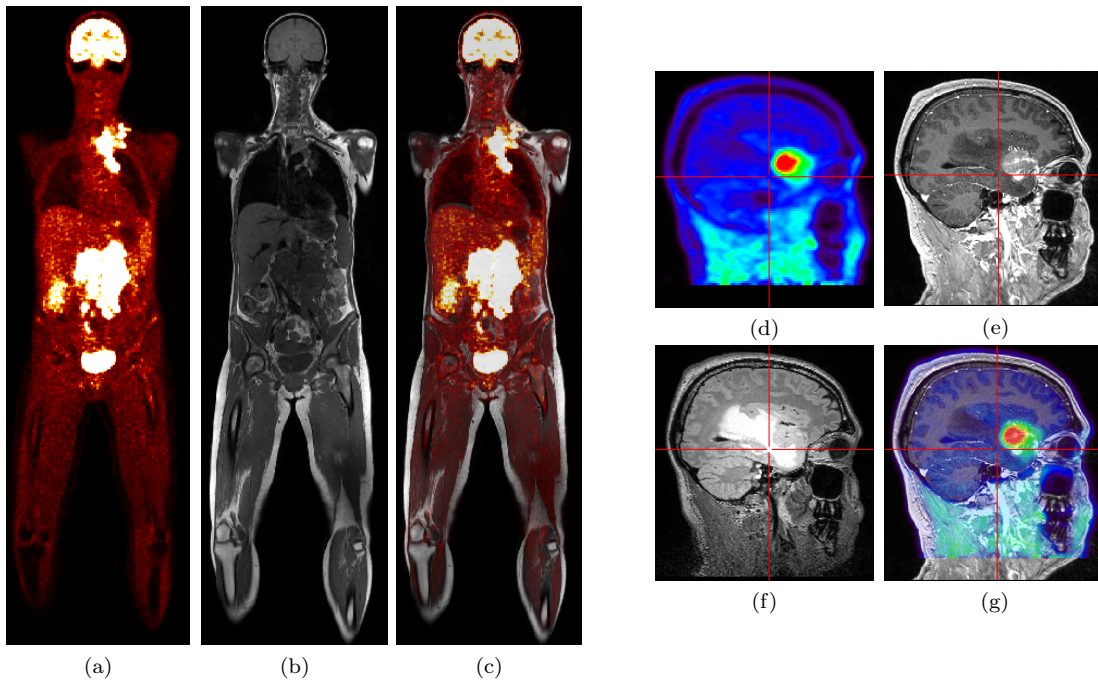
Examples of PET and MR images acquired with a Siemens Biograph mMR scanner. The images show cancer patients who underwent a whole-body (a)-(c) and a brain only (d)-(g) scan. (a) Coronal PET image that maps the distribution of  $[^{18}\text{F}]\text{FDG}$ , i.e., glucose consumption in the human body thus highlighting metabolically active areas. Normal high  $[^{18}\text{F}]\text{FDG}$  uptake is found in the brain, the kidneys and the bladder. Lesions showing abnormal high  $[^{18}\text{F}]\text{FDG}$  uptake are visible in the abdomen and thorax of the patient. (b) Corresponding T1-weighted MR image (MPRAGE) after contrast agent injection. It provides high-resolution anatomical detail. (c) Fused view with the PET image overlaid on top of the MR image. The MR image provides precise anatomic localization and delineation of PET abnormalities. (d) Sagittal PET image of the brain using  $[^{18}\text{F}]\text{FET}$ , an amino acid PET tracer, clearly showing a tumor in the patient's head.  $[^{18}\text{F}]\text{FET}$  imaging provides better tumor to normal tissue contrast than  $[^{18}\text{F}]\text{FDG}$  imaging. (e) Corresponding MR image of the patient's head using a T1-weighted (MPRAGE) sequence and (f) a T2-weighted sequence that shows brain anatomy also revealing structural changes in the patient's brain. (g) Fused view with the PET image overlaid on top of the MPRAGE image.
